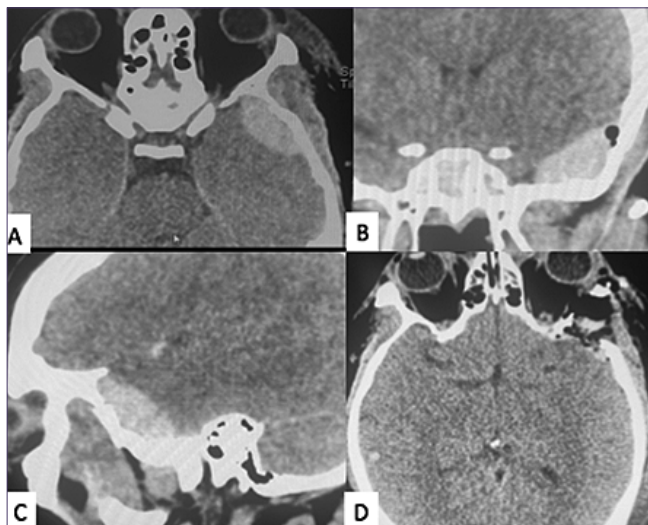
Evacuation of extradural hematoma. A-C: Preoperative axial; (A) coronal (B), and sagittal (C) CT images showing an extradural hematoma located on the left temporal pole, with adjacent mass effect, in a patient with closed head trauma and a Glasgow Coma score of 15. D: Postoperative CT scan showing resolution of the hematoma after evacuation via the TOMS approach. The access allowed direct exposure of the temporal pole.
